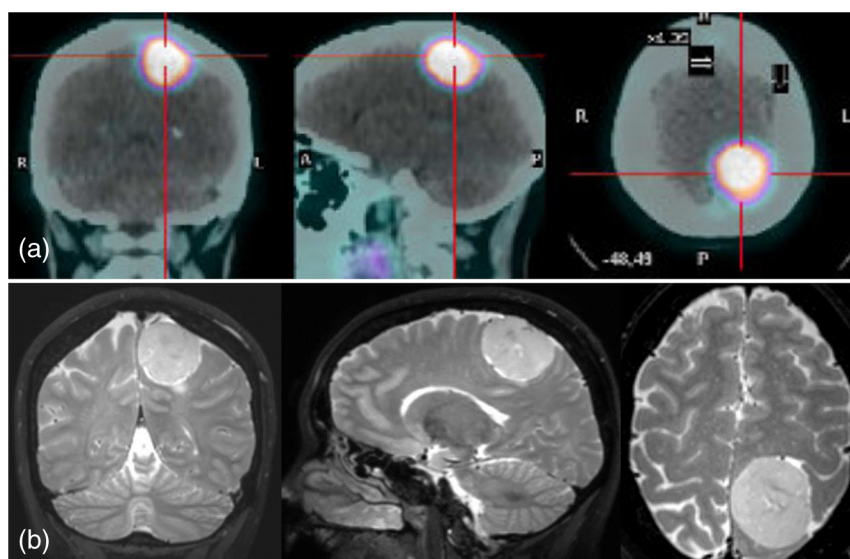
(a) The coronal, sagittal, and axial PET-CT images of the patient injected with ^{68}Ga -DOTATOC. The PET images were used to estimate the activity concentration of ^{90}Y -DOTATOC in the tumor during surgery. (b) The T2 MR images of the patient acquired without contrast medium.
